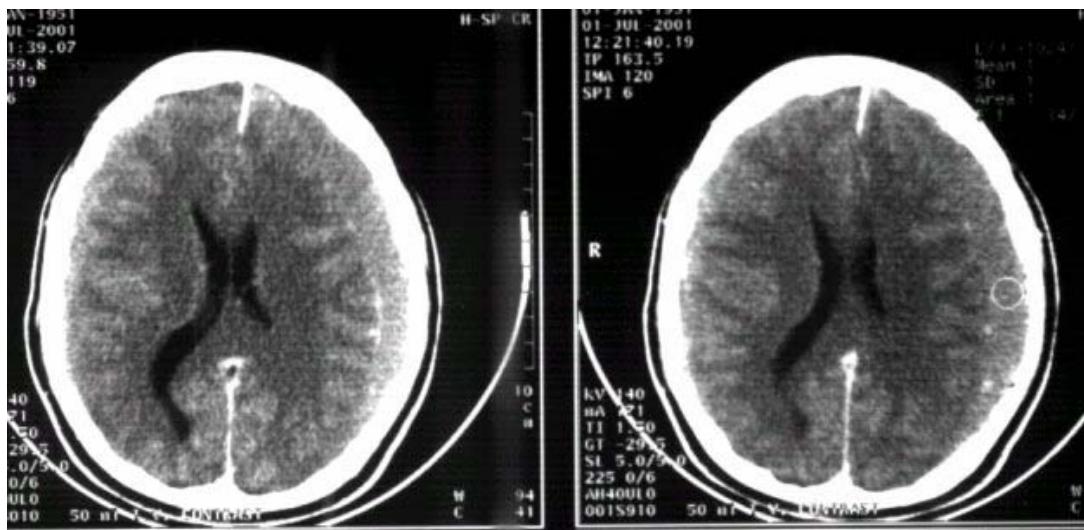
Axial CT. Lt. CSH Isodense to the brain
